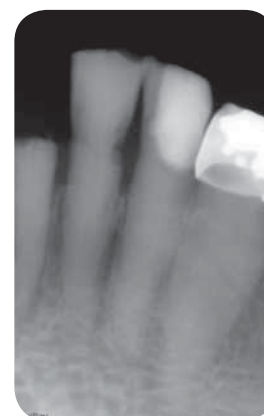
Radiograph of tooth No. 25 shows periapical pathology.
